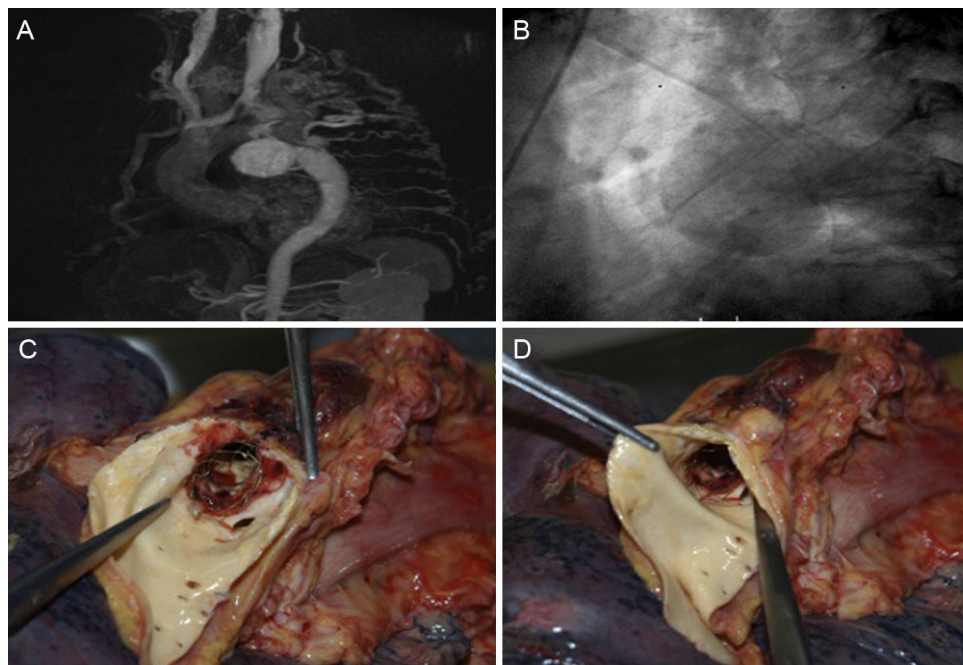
magnetic resonance image showing extensive collateral circulation, contrast enhancement of the descending aorta, and a giant intercostal aneurysm. B: late phases of the aortic angiogram show extensive collateral circulation to the descending aorta and a giant intercostal aneurysm. C and D: autopsy image showing loss of the stent cover.
